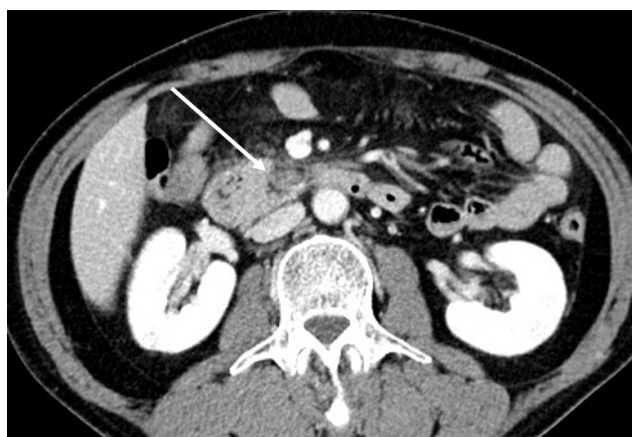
Computed tomography performed 6 months after discharge. Marked decreased size of the previously noted mass-like lesion with mild haziness in the retroperitoneal space, suggesting an improving state of organizing hematoma with adjacent fibrotic changes (arrow).
